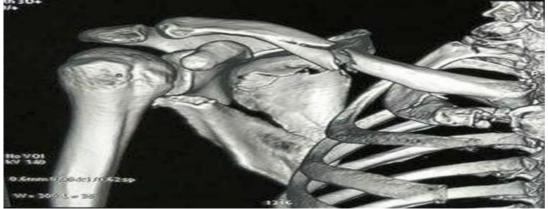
Case 1: Pre-op 3-D CT Scan (Clavicle Type I, Scapula Goss Type II GPA <30°)
